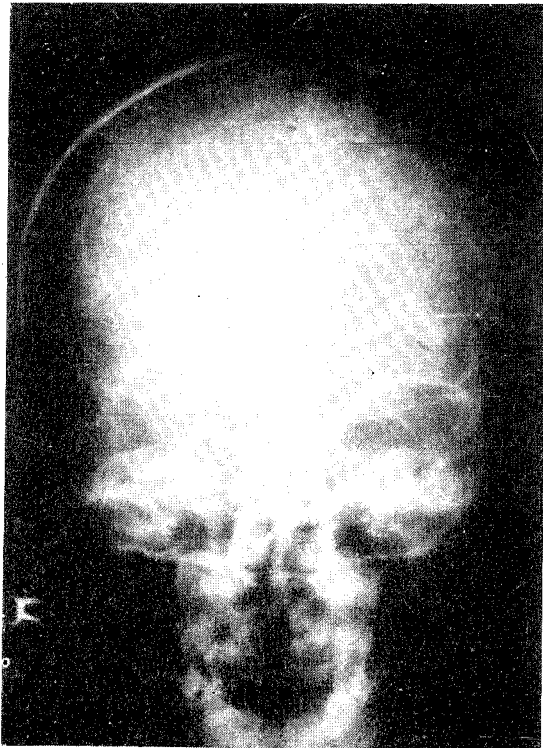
X-ray skull of the patient.
